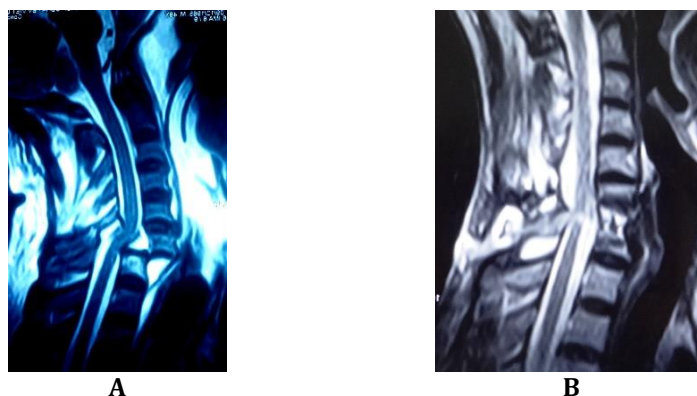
A T2-weighted MR pre-operation. Despite complete dislocation of the vertebral body, cerebrospinal fluid (CSF) was present in the dorsal side of the spinal cord, because of multiple posterior fractures, widening the spinal canal itself. B. T2-weighted MRI 6 weeks post-operation. Spinal straightening result were good, the CSF was circulating, but leakage of the cerebrospinal fluid from the point of incision could be observed.
